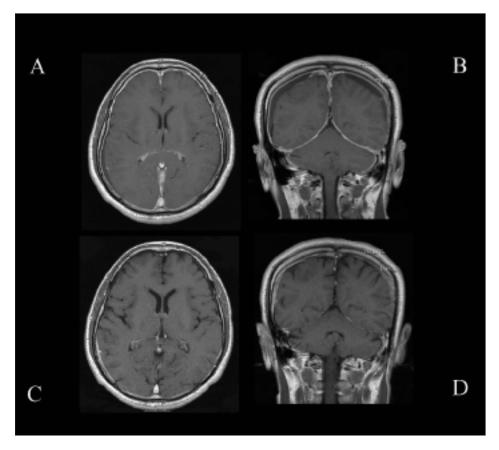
Axial (A) and coronal (B) post-gadolinium enhancement T1-weighted (repetition time/echo time[TR/TE]=560/12 ms) magnetic resonance images from Patient 1. Pretreatment images (A, B) demonstrating pachymeningeal enhancement and supratentorial subdural effusions. Post-treatment images (C, D) demonstrated resolution of these findings.
